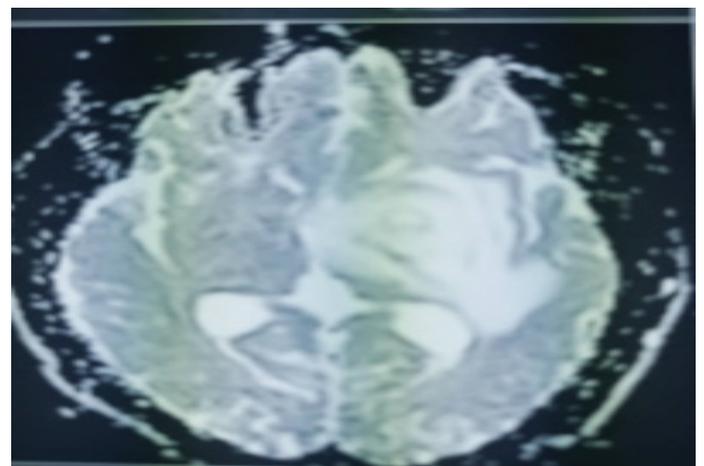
Contrast enhanced brain MRI showing ring enhancement in the left basal ganglia region with non-restricting capsule, significant peri-lesion oedema and midline shift to contralateral side compatible with tuberculoma.
